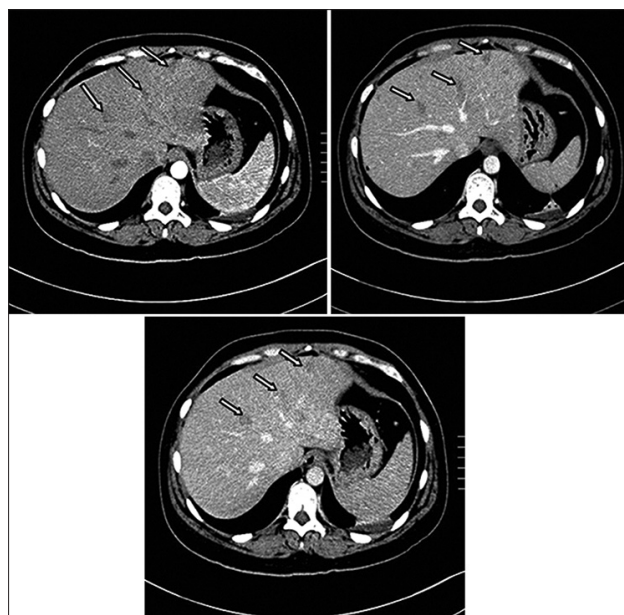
Low-density shadows of the abdominal computed tomography.
